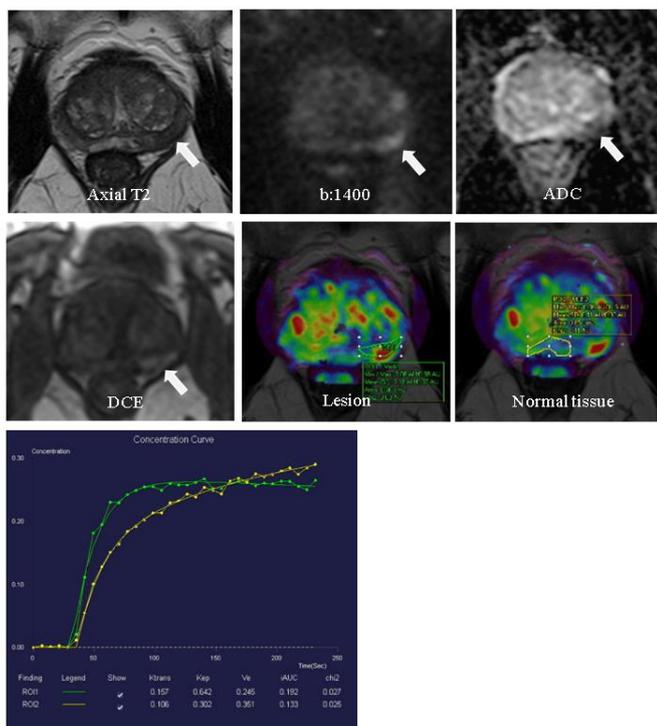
Multiparametric MRI and quantitative DCE-MRI results of a 73-year-old male with a PSA of 4.77 ng/ml and PSAd of 0.08 ng/ml/cm3. Arrows are showing a PI-RADS category 5 lesion placed on left mid-peripheral zone. Green curve is representing the lesion whereas yellow curve is showing normal prostate. Lesion Ktrams, Kep, Ve, and iAUC values are 0.157, 0.642, 0.245 and 0.192, respectively. Lesion/normal ratios of Ktrams, Kep, Ve, and iAUC are 1.49, 2.13, 0.70 and 1.44, respectively. The lesion was Gleason 4+3 tumor in whole-mount report.
